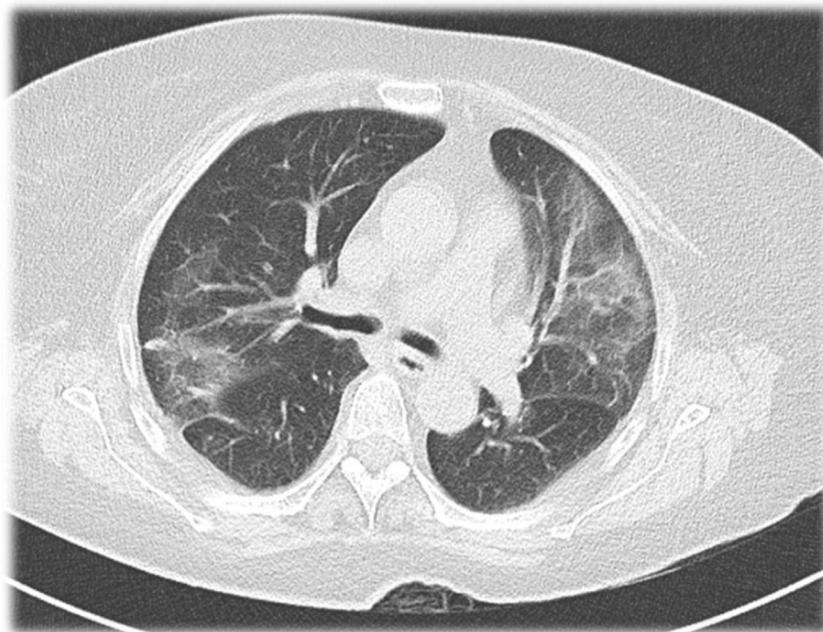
Thorax CT showing multifocal patchy air-space consolidations, ground-glass opacities.
